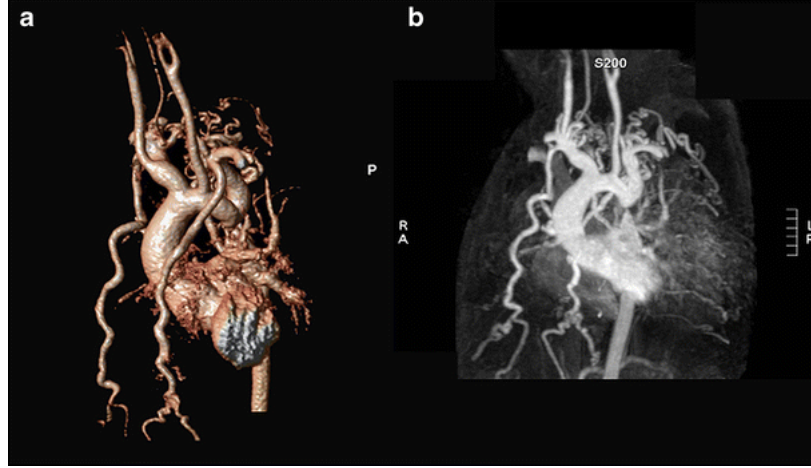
Magnetic resonance imaging representing collaterals in aortic coarctation pathology [LBMdW12].
